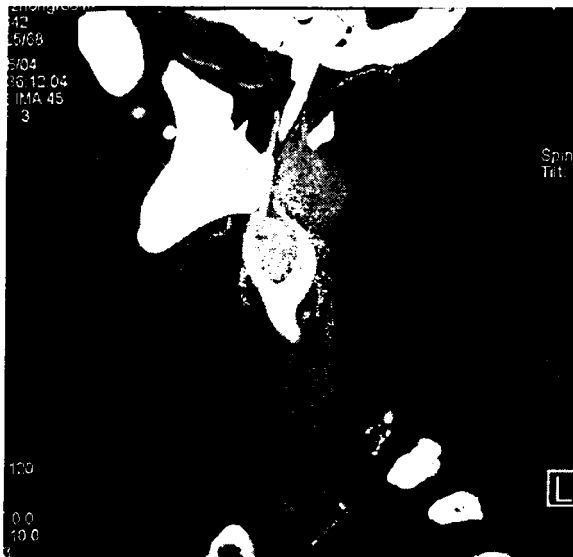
Sagittal CT of a 36-year-old man with a midcervical mass showed 2 tumors, 1 splaying the carotid bifurcation and the other locating cranially to the bifurcation.
